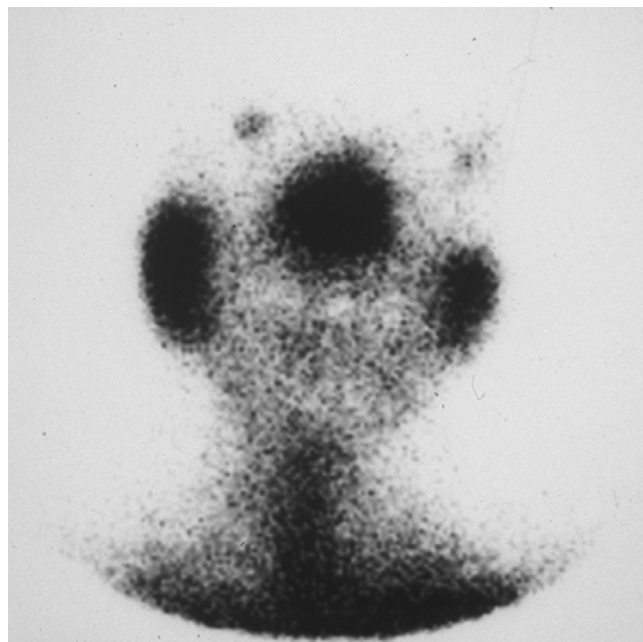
The “snowman” sign. Gallium-67 scintigraphy of the parotid glands of a patient with diffuse infiltrative lymphocytosis syndrome occurring in the setting of hemophilia.
